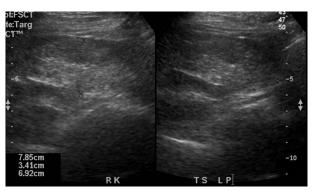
Ultrasound of the right kidney
